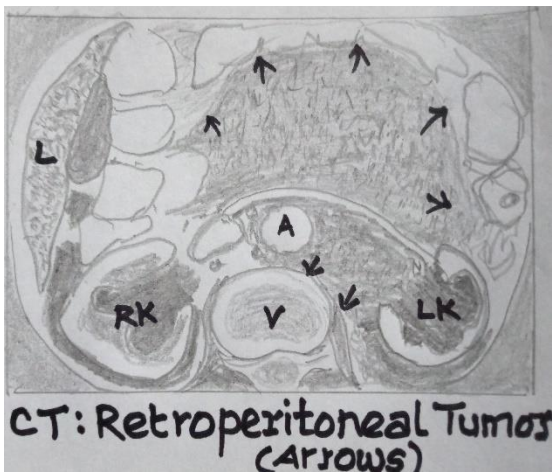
CT: Retroperitoneal mass causing bilateral hydronephrosis
